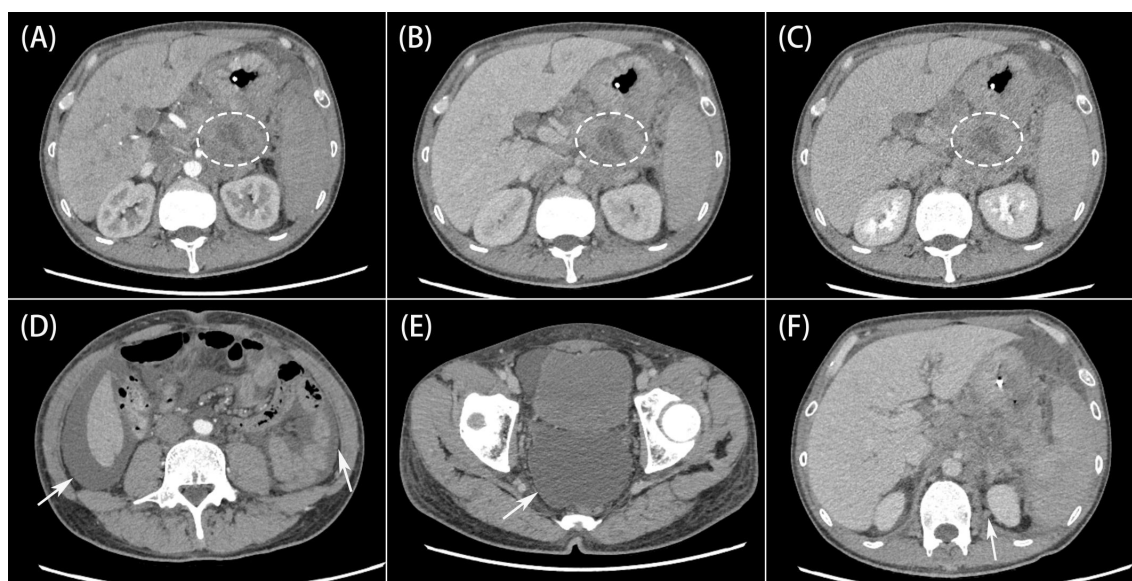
Imaging presentation of the tumor. Enhanced CT suggests structural destruction of the tail of the pancreatic body, multiple foci of mixed hypodensity, and multiple peripancreatic exudates, (A, B, C). It is poorly demarcated from the stomach, duodenum and colonic splenic flexure. Abdominopelvic fluid accumulation is massive (D, E). Multiple soft tissue densities in the retroperitoneum, visible as enlarged lymph nodes in the left retroperitoneum indicated by the arrow (F).
